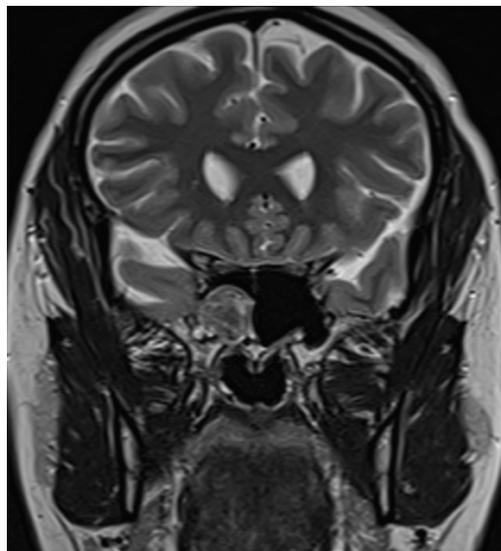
Coronal T2-weighted MRI demonstrating high-resolution visualization of the ventricles and temporal lobes, with evidence of brain herniation into the right recess of the sphenoid sinus.
